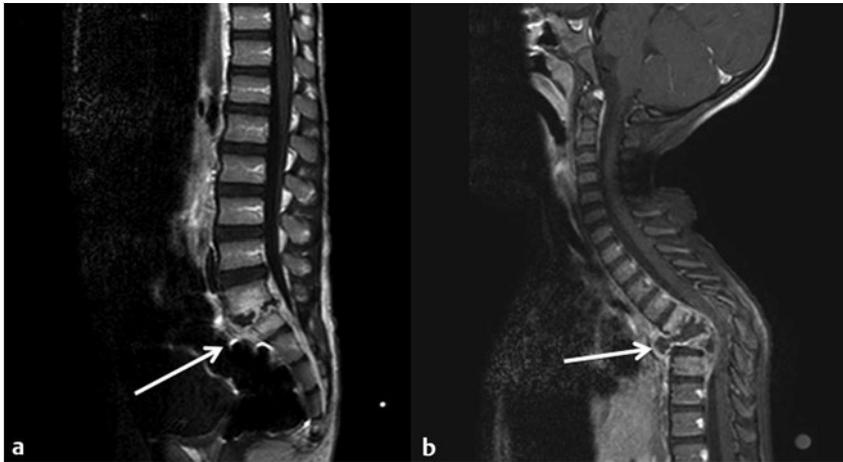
(a) Sagittal postcontrast magnetic resonance (MR) image of the lumbar spine showing a pyogenic infection centered at the disk space with epidural extension (*white arrow*). (b) Sagittal postcontrast MR image of the thoracic spine of a patient with a tuberculous infection shows relative preservation of the adjacent disk spaces but significant involvement of the vertebral bodies (*white arrow*).
